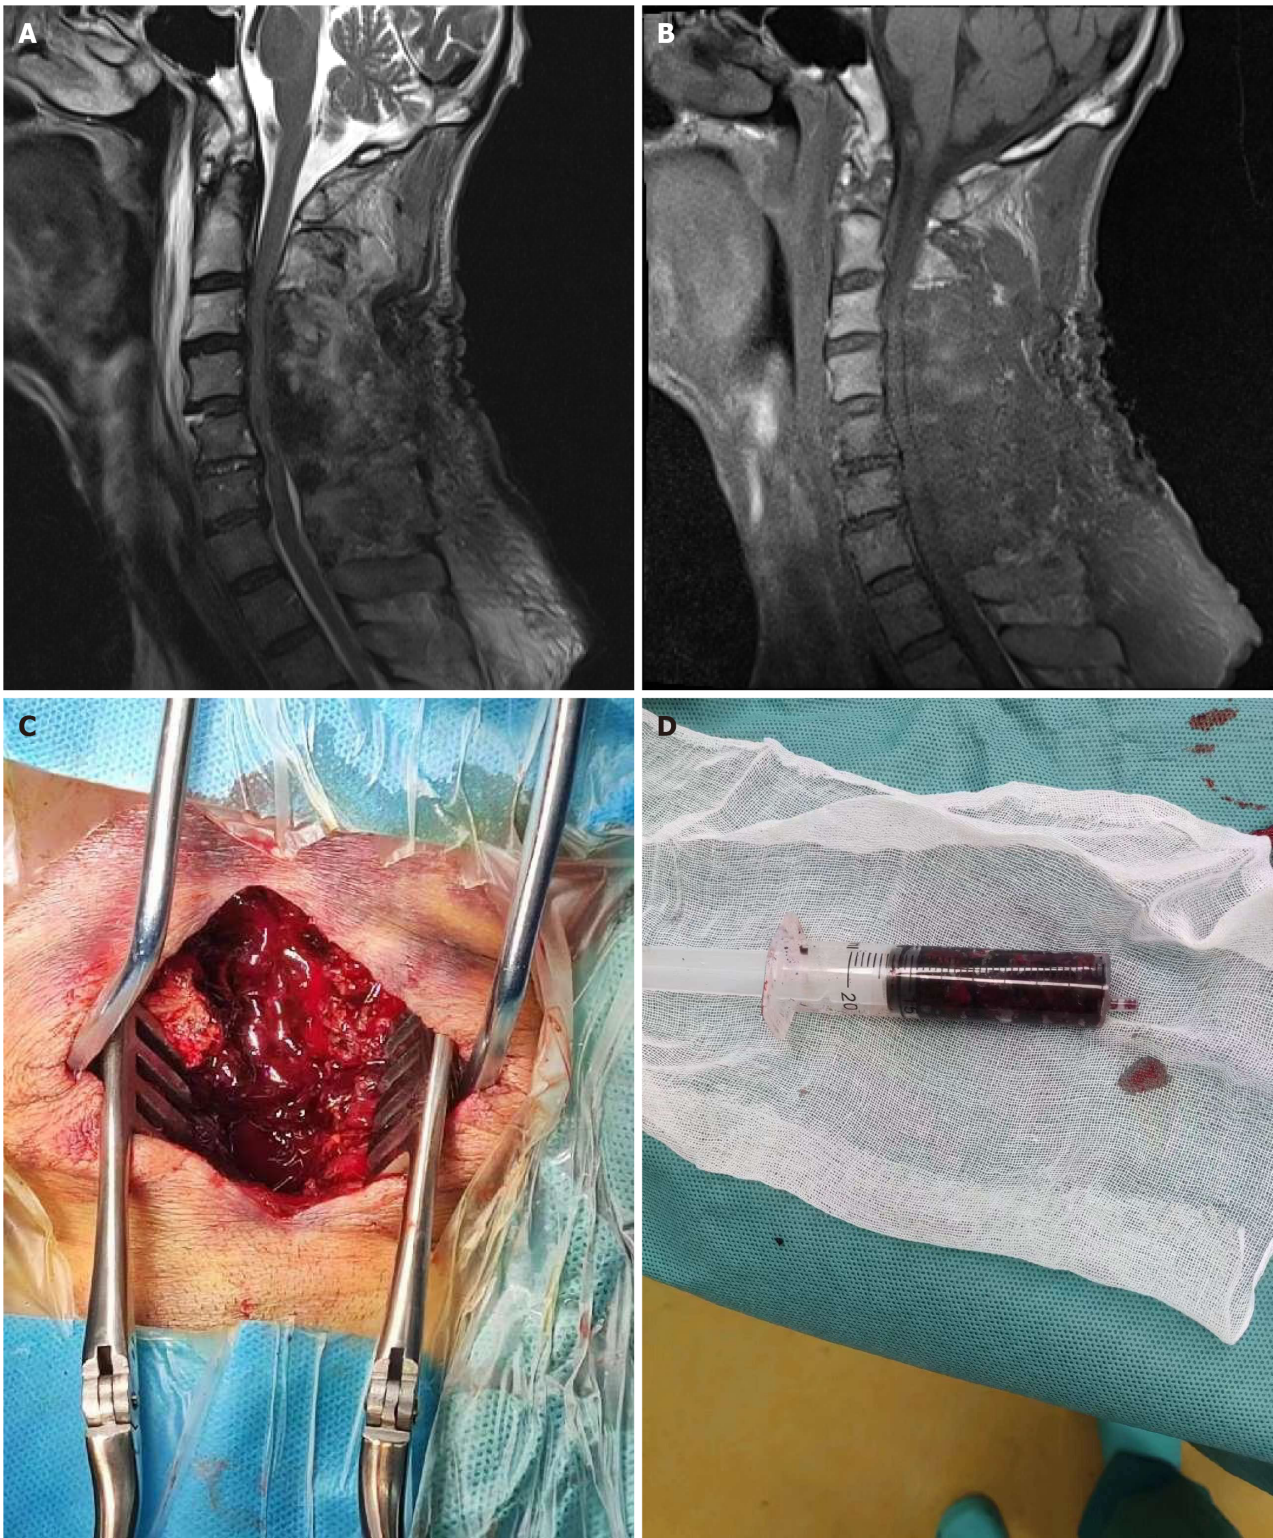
Postoperative magnetic resonance imaging obtained 8 h after symptom onset and the intraoperative view. A: Magnetic resonance imaging (MRI) showing heterogeneous intensity on T2 weighted imaging (T2WI); B: MRI showing an isointense low signal intensity on T1WI with marked indentation on the dural sac; C and D: Intraoperative image showing the spinal epidural hematoma.
